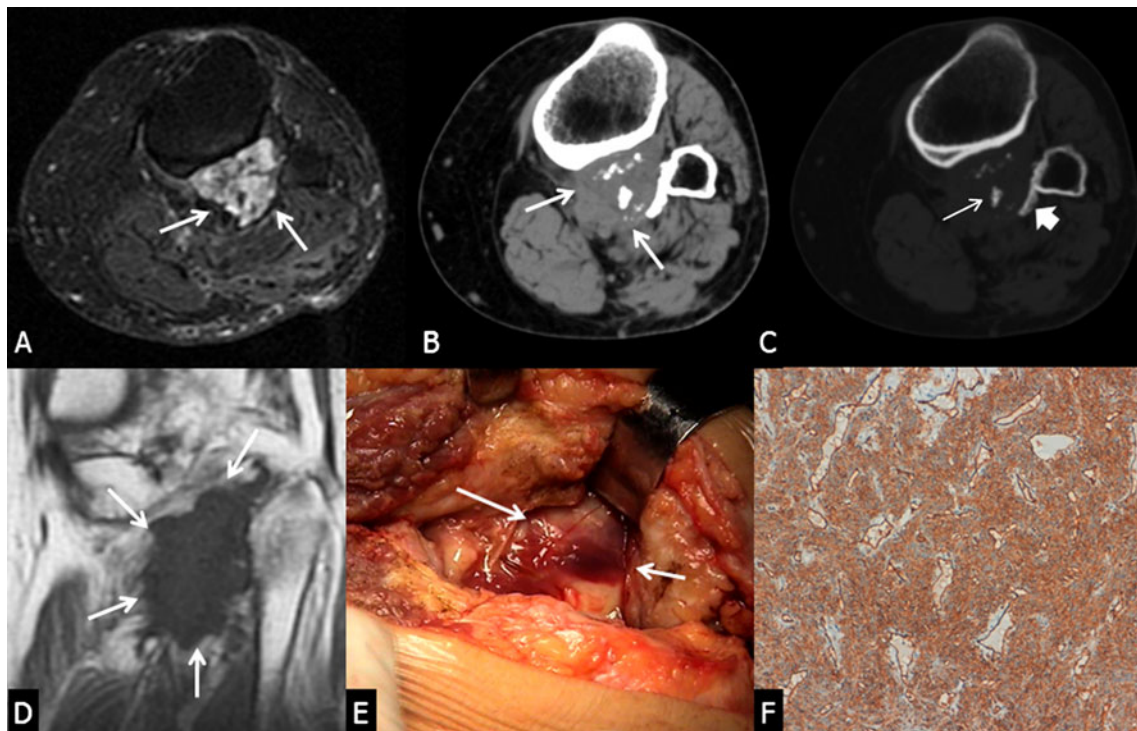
IMT of left leg. MR axial FSE T2-weighted fat-saturated image (a) shows the presence of inhomogeneous polylobulated mass at the level of popliteal fossa (*arrows*). CT scan (b) confirms the presence of inhomogeneous mass (*arrows*) and the same CT slice with bone window (c) better defines the presence of central-lesional areas of non-structured and non-confluent gross calcifications (*thin arrow*)
